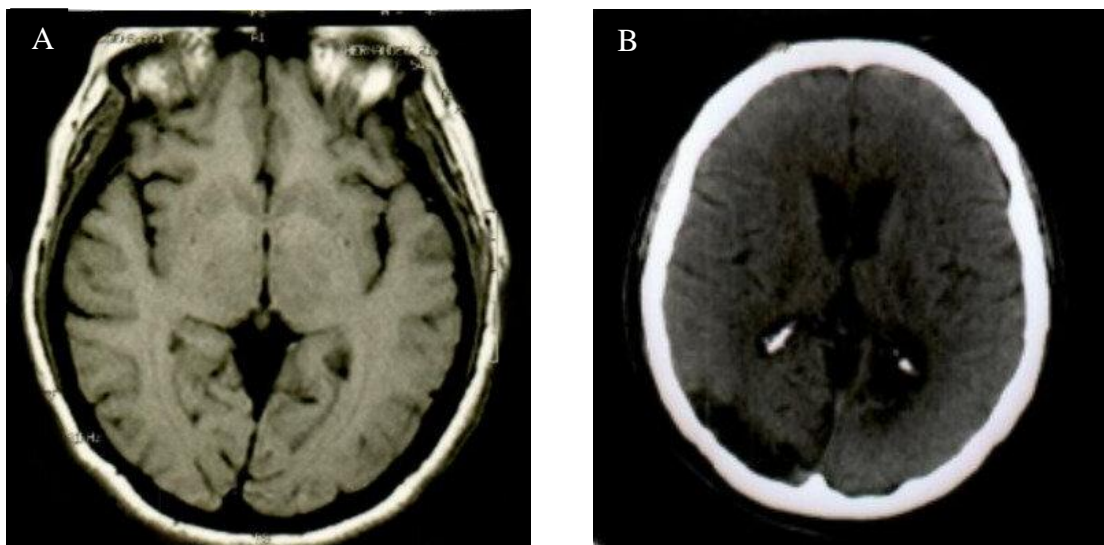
(A) Magnetic resonance imaging without evidence of lesions in the initial assessment.
